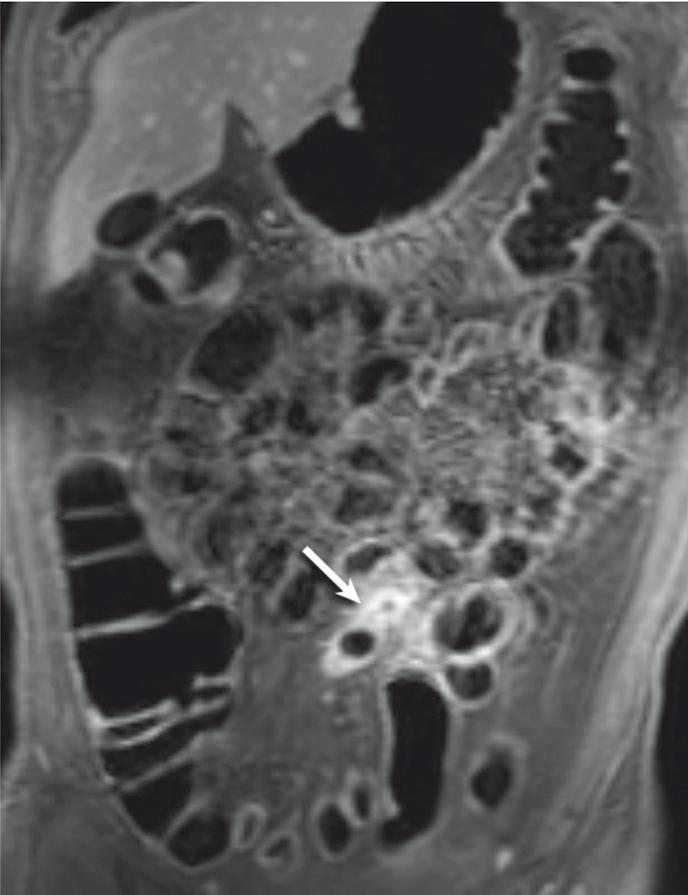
A 37-year-old male with episodes of rectal blood loss and anemia without previously identified focus. Magnetic resonance enteroclysis revealed a Meckel's diverticulum with increased enhancement in the proximal ileum (arrow) on the coronal 3D T1-weighted fat-saturated image after contrast injection. Video capsule endoscopy (not shown) was not performed due to high grade small bowel stenosis at the Meckel's diverticulum. Balloon-assisted enteroscopy (not shown) was incomplete with a limited anal approach missing the actual lesion. Surgical resection confirmed the diagnosis of a Meckel's diverticulum.
